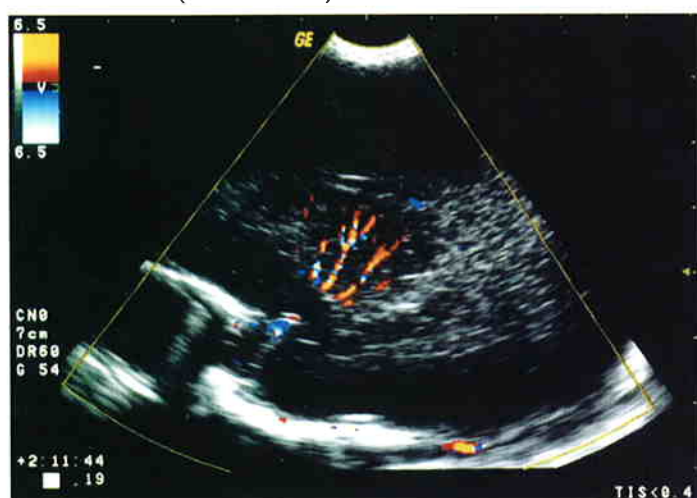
Colour Doppler imaging of the lenticulostriate arteries (sagittal view)
